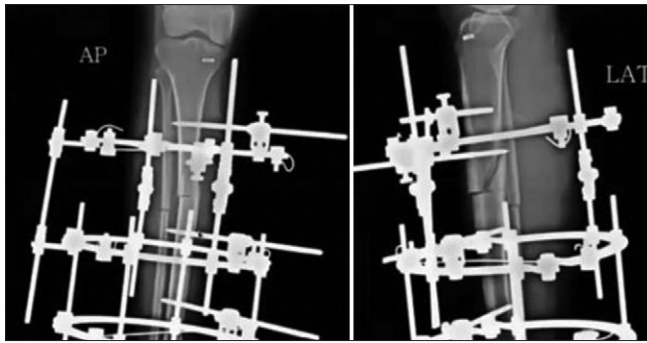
Postoperative X-ray showing the application of the Ilizarov apparatus. Due to the proximal propagation of the osteotomy, distraction was delayed
